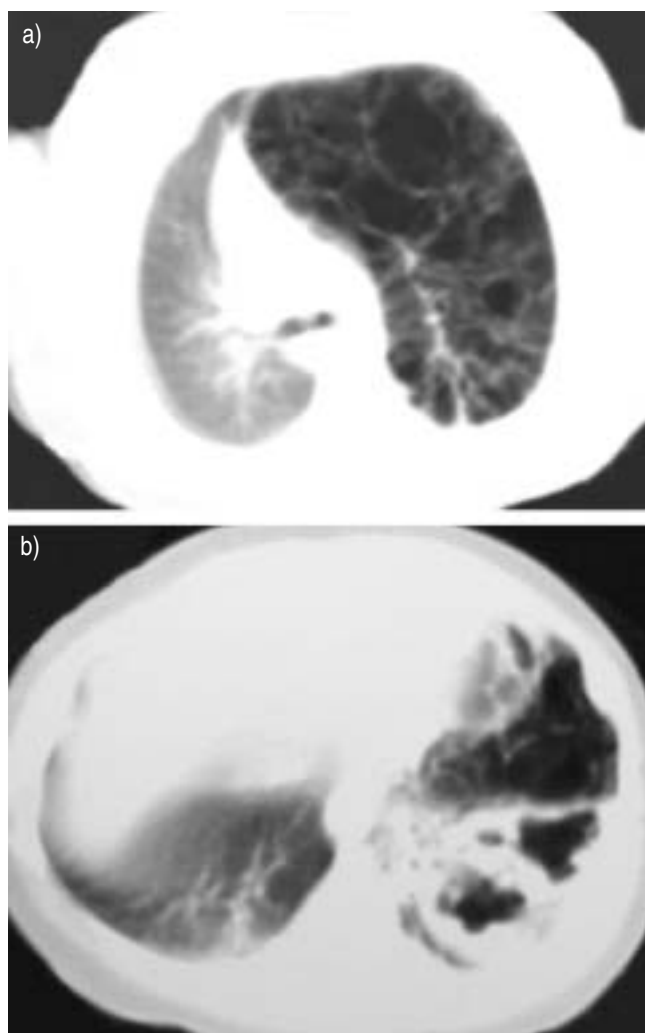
Initial computed tomography of the chest showing: a) upper and b) lower lung lobes.
